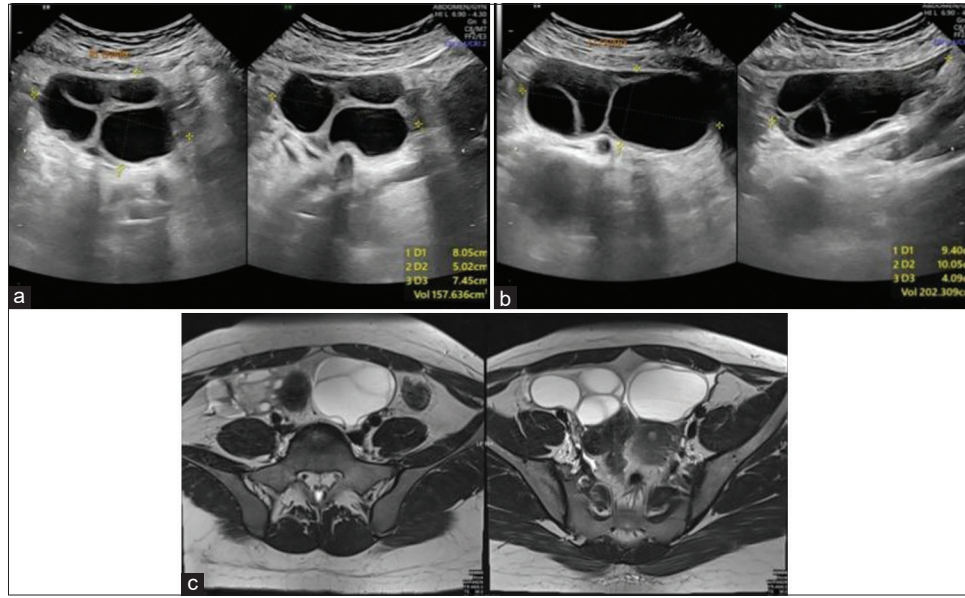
A 19-year-old female presented with ovarian hyperstimulation syndrome who presented with severe abdominal pain (a and b) ultrasound images showing bulky bilateral ovaries with multiple enlarged follicles and (c) axial T2-weighted magnetic resonance imaging section of the pelvis re-demonstrating the ultrasound findings of bulky ovaries with multiple follicles. No e/o torsion was noted.
